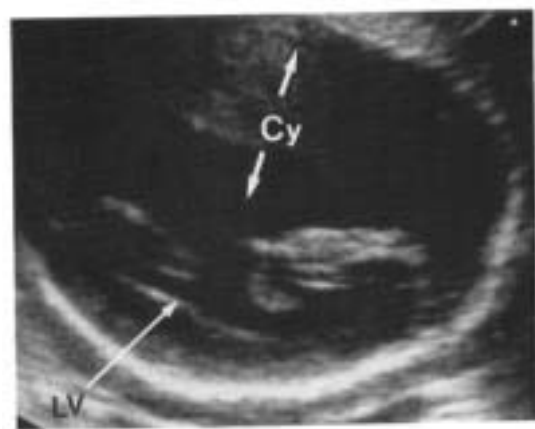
Axial scan of the head of a 32-week fetus with severe porencephaly. The cerebral hemisphere that is closer to the transducer is entirely replaced by a cystic structure (Cy). Note the marked shift of the midline and the mildly enlarged contralateral ventricle (LV). (Reproduced with permission from Pilu et al.: *Ultrasound Med Biol* 12:319, 1986.)
